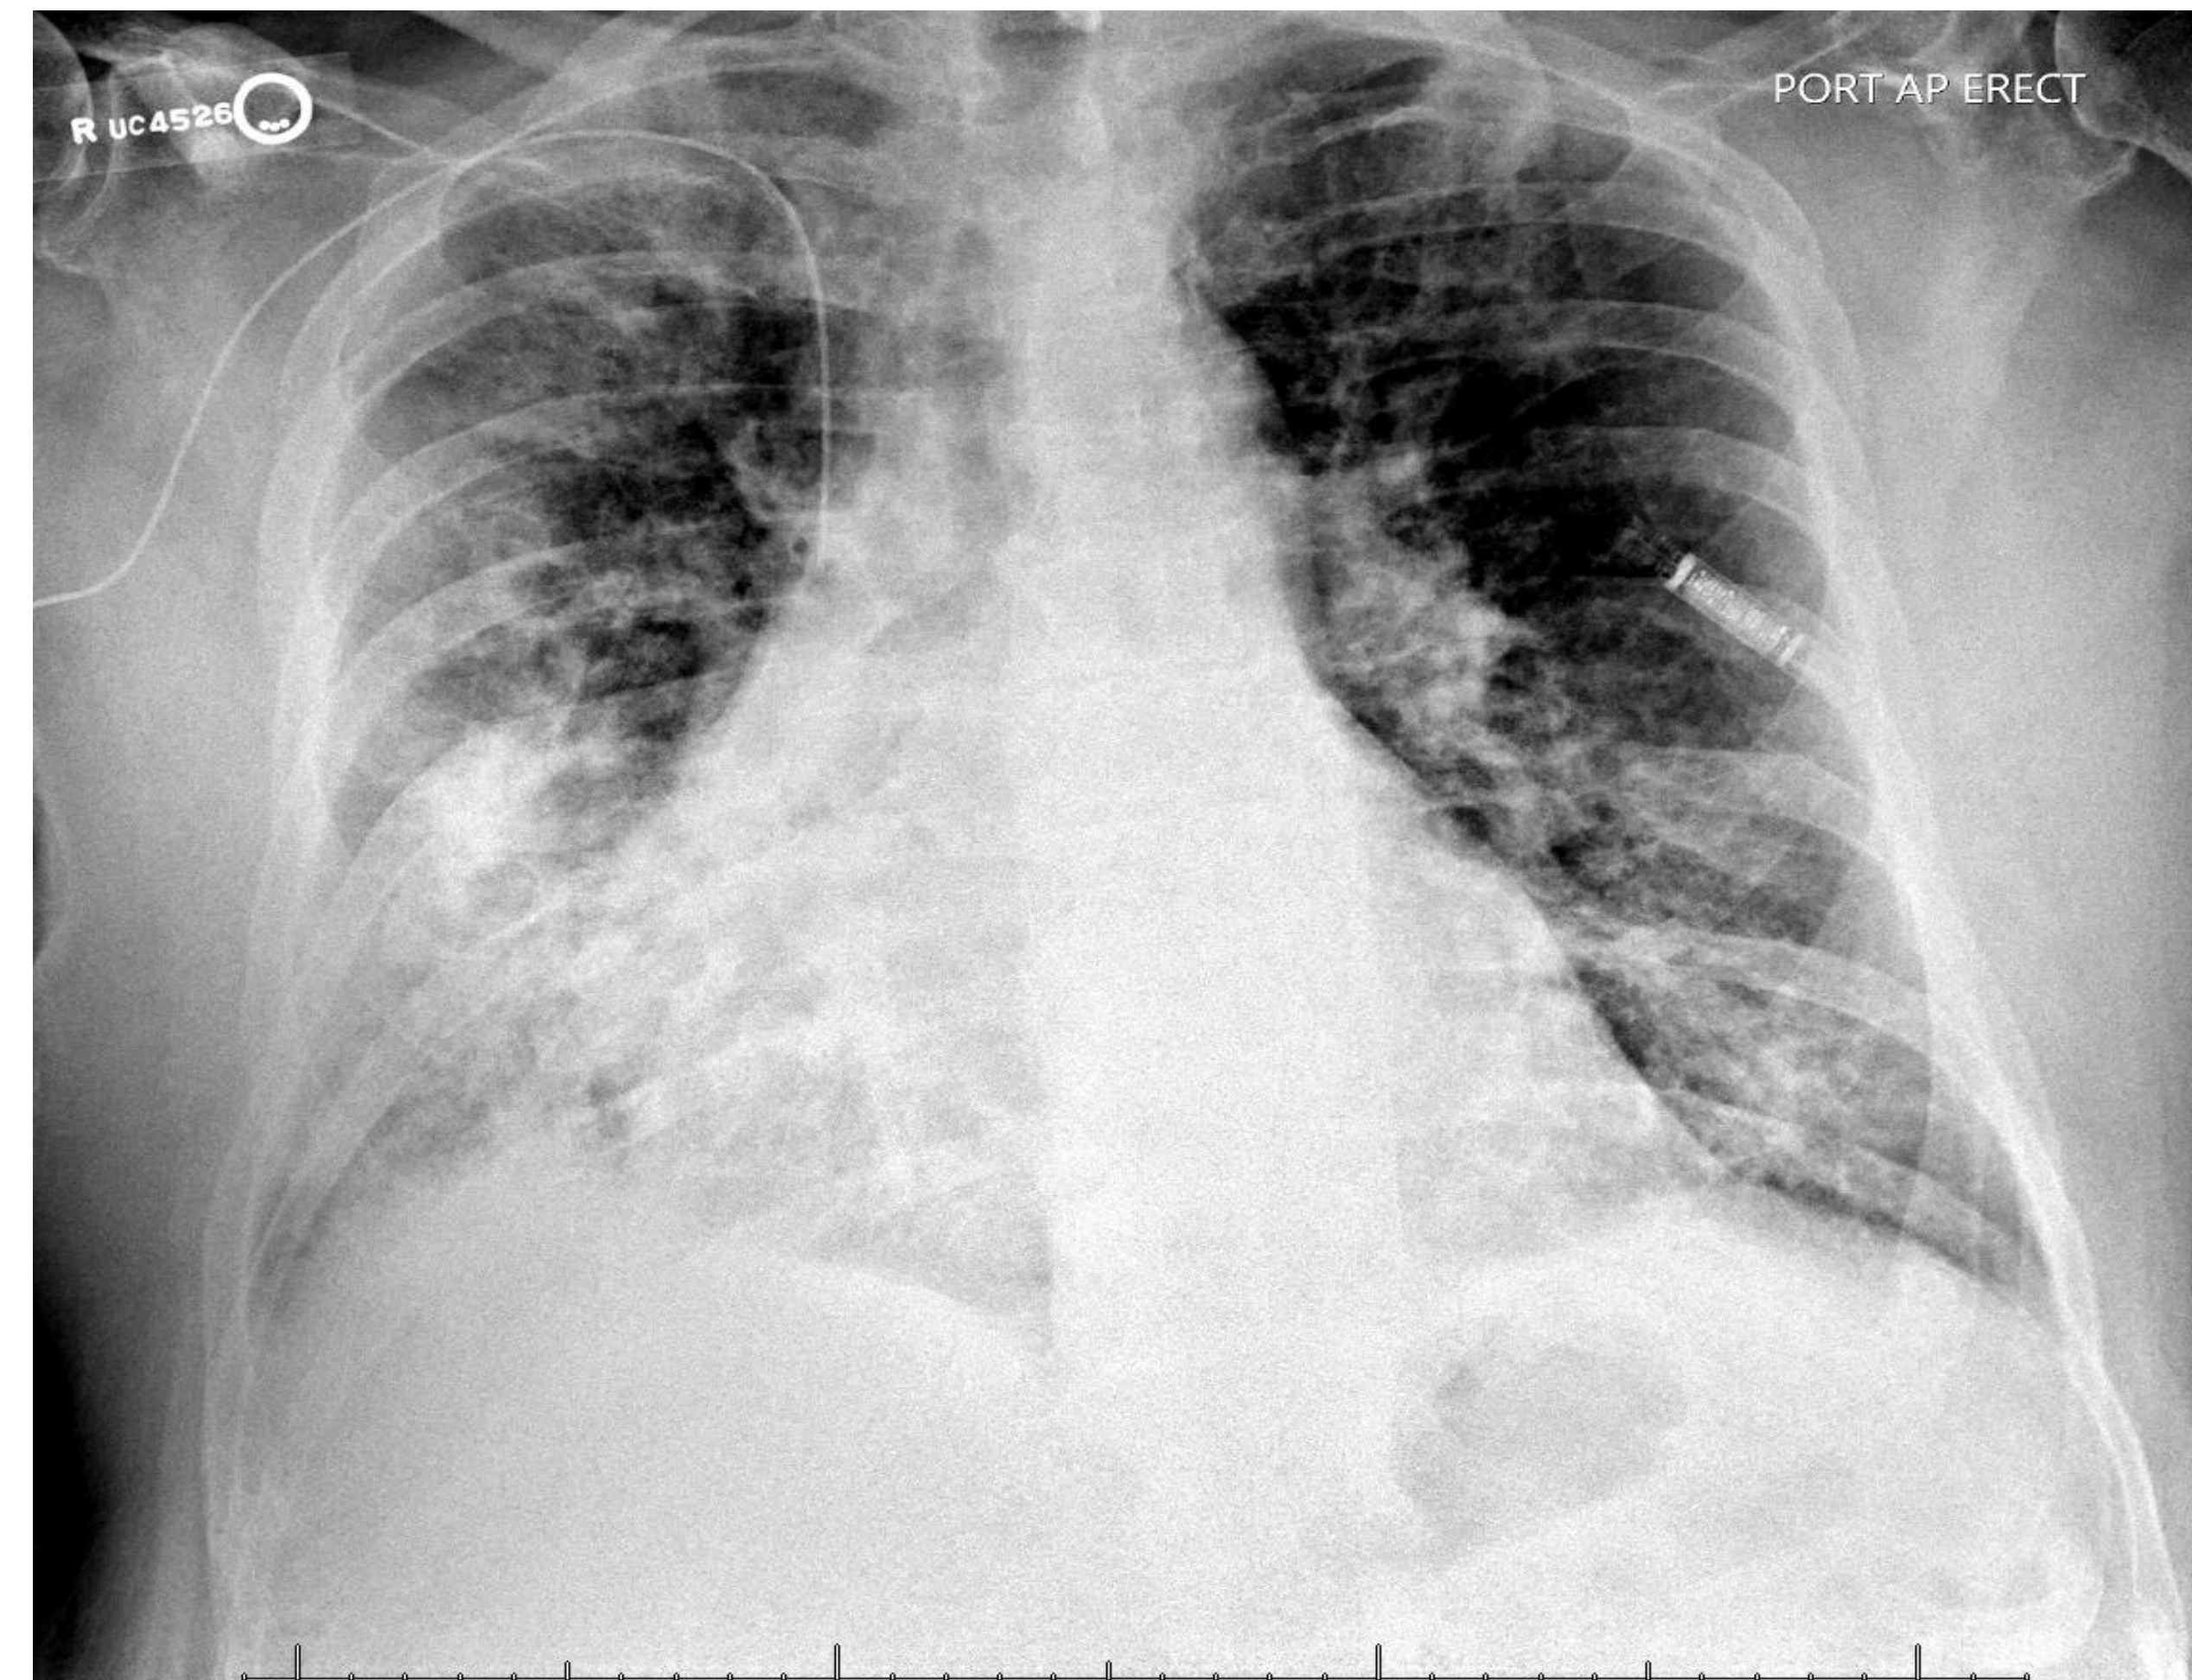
Chest radiograph at presentation showing diffuse bilateral patchy infiltrates.
